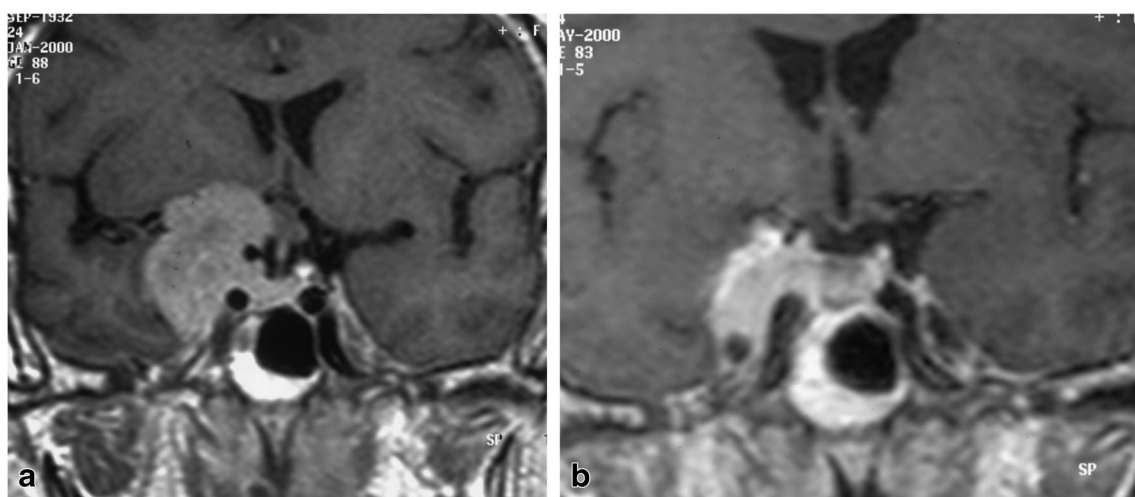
Preoperative coronal view on MR enhanced T1-weighted images showing primary exophytic cavernous sinus meningioma (a). Postoperative scans showing cytoreduction (b). This patient underwent adjuvant SRS
